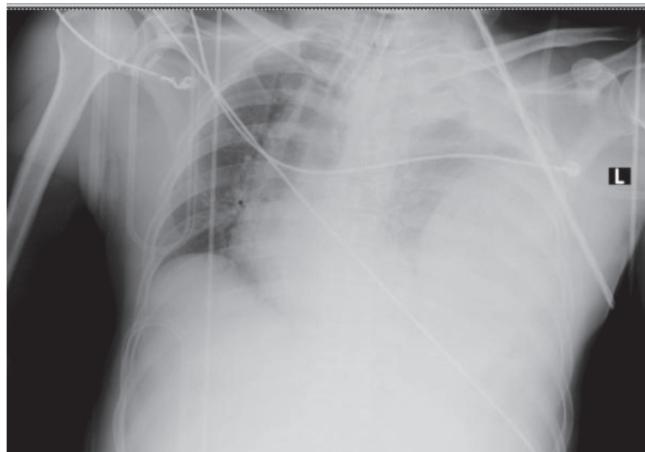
chest radiography shows marked elevation of left side of the diaphragm, haziness of left hemithorax and mediastinum shift to the right.
